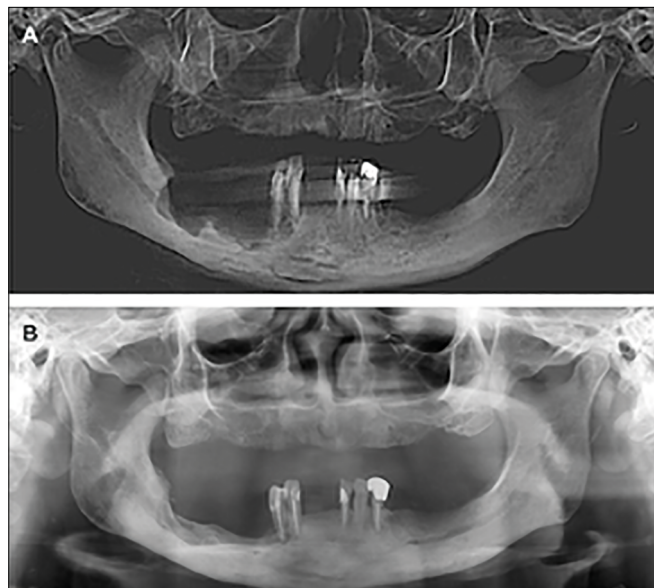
A- Panoramic reconstruction from an immediate post-surgery computed tomography showed the presence of regulated bone margins and no fragments of necrotic bone in the right mandible body. B - At a two-year panoramic radiograph follow-up, sclerosis of the mandibular bone – neoformed bone – with no signs of osteolysis or sequestrum could be observed.
